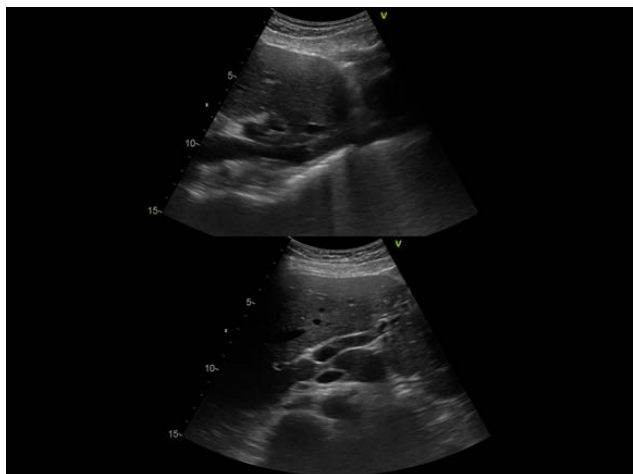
Abdominal ultrasound on arrival. No air bubbles were observed in the inferior vena cava or portal vein
